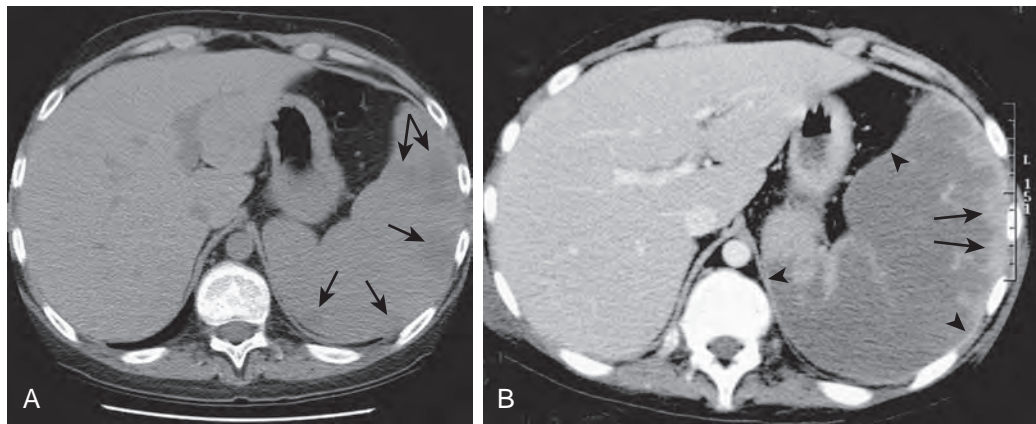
Leukemia and infarction. A. Noncontrast CT performed to assess pulmonary infection demonstrates splenomegaly in a teenager with leukemia. Peripherally located, hypoattenuating areas (arrows) may represent areas of infarction, infection, or tumor infiltration. B. Contrast-enhanced CT obtained 13 days later to evaluate the acute onset of left upper quadrant pain demonstrates an interval increase in spleen size. The spleen has a large area of decreased attenuation and relative lack of enhancement. The capsule (arrowheads) and some peripheral parenchyma (arrows) have normal attenuation and enhancement. Splenectomy confirmed splenic infarction.
